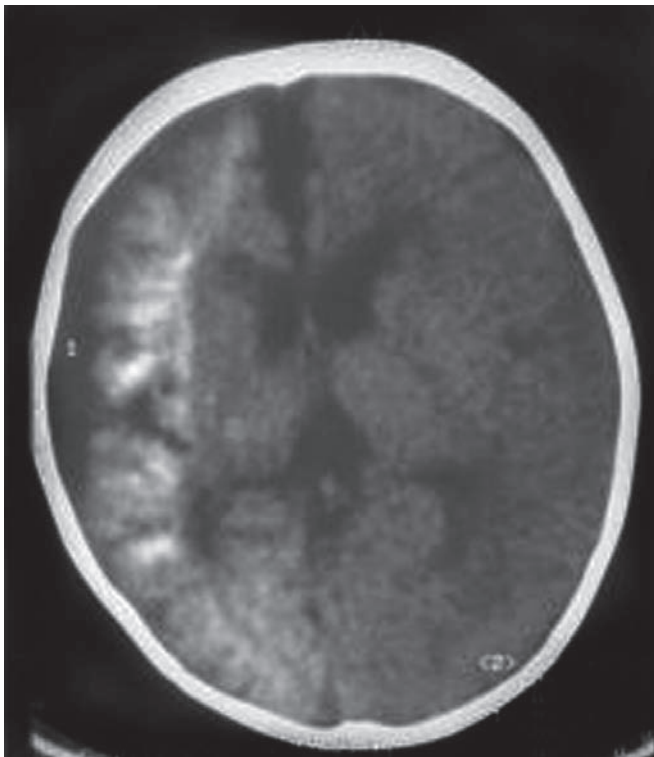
Sturge-Weber syndrome. CT scan showing intracranial calcification
